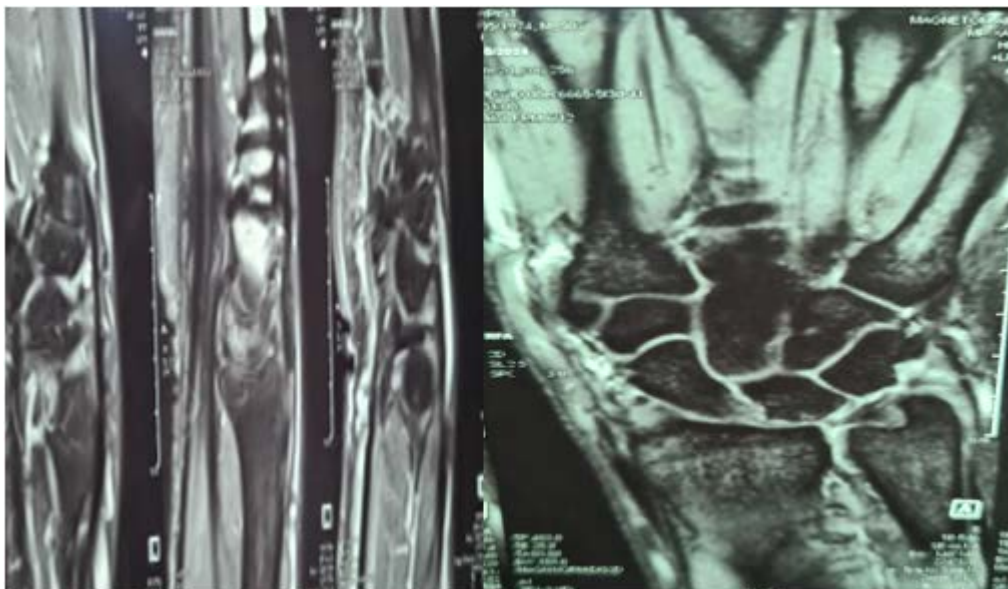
MRI 12 months' post-operative showing better lunate revascularization.
